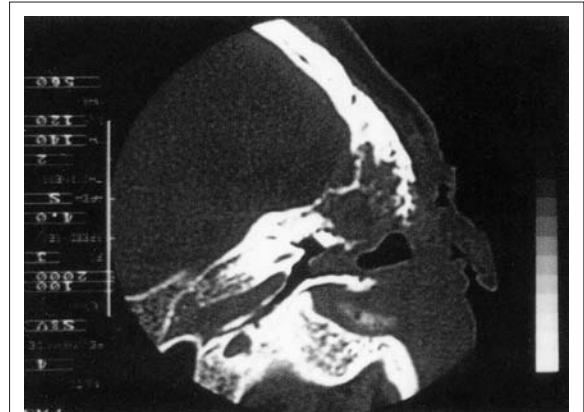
High resolution CT scan showing lesion occupying external auditory canal.
